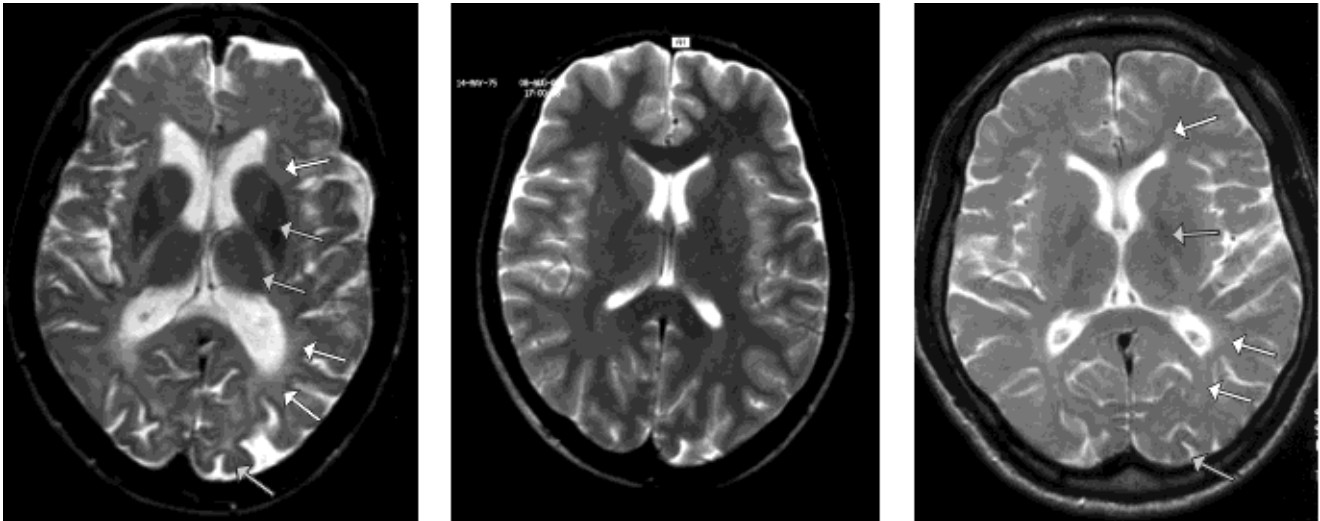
(A) An axial spin-echo sequence image (TR 4000/TE 90/TA 2:28) of case 1 demonstrates hypointensity of the cortex, caudate nucleus and the thalamus (grey arrows), periventricular white matter hyperintensity, particularly pronounced in the occipital lobes (white arrows) as well as mild cerebral atrophy in the same plane as figure 4. (B) Axial spin-echo sequence image (TR 4000/TE 90/TA 2:28) of a normal person in the same plane as fig. 1A and 1C. (C) The axial T2-weighted image of case 2 (TR 2700/TE 90/TA 8:42) shows periventricular leukodystrophic changes (white arrows) and hypointensity in the basal ganglia and the occipital cortex (grey arrows).
